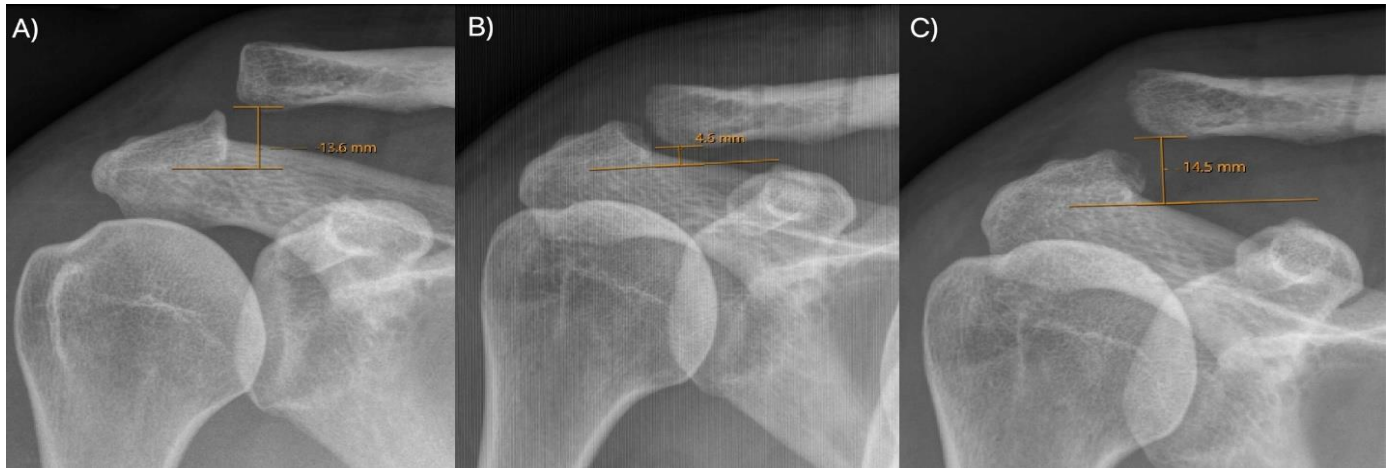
Preoperative (A), immediate postoperative (B), and final postoperative (C) shoulder radiographs for a 27-year-old female who experienced structural failure following open suture reconstruction of a chronic type V acromioclavicular joint injury
